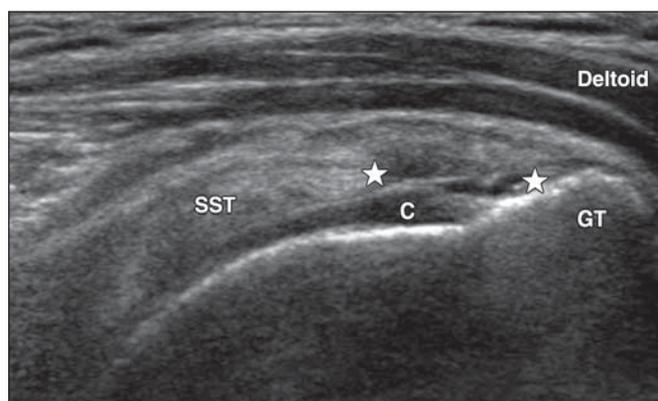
55-year-old man with asymptomatic partial-thickness tear of articular surface of supraspinatus tendon. Long-axis ultrasound image of supraspinatus tendon shows hypoechoic articular surface tear (between stars) and intact bursal fibers overlying articular surface tear. SST = supraspinatus tendon, C = cartilage, GT = greater tuberosity.
